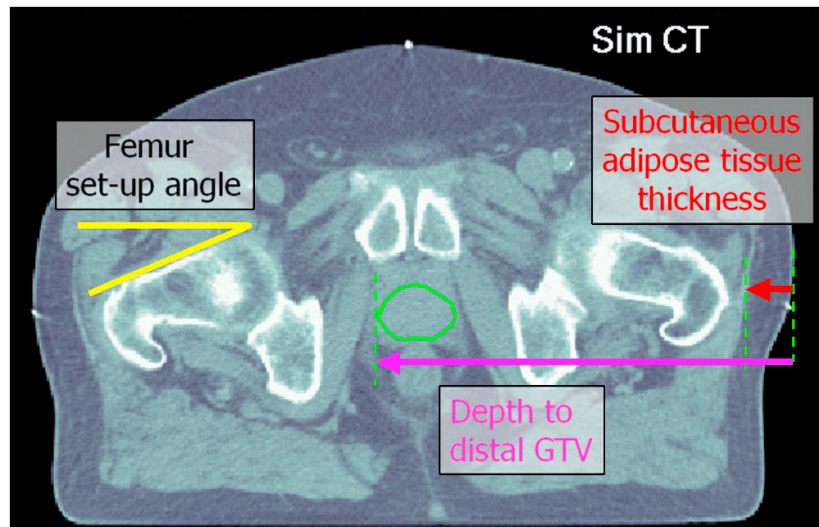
Parameters estimated from serial CT data (Patient 5). All distances were measured from the skin surface at the iso-center level. The femur angles were measured 1 cm below the superior surface of the *collum femoris*.
